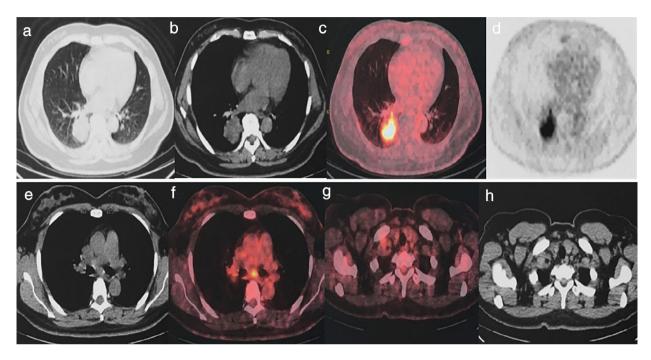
18F-FDG-positron emission tomography/computed tomography (PET-CT) showed a lung nodule about 4.4 × 4.1 cm in size (SUVmax 10.5) in the basal segment of the right lower lobe (a–d), with mediastinal, right hilum and right supraclavicular lymph node enlargement (SUVmax4.9) (e–h)
